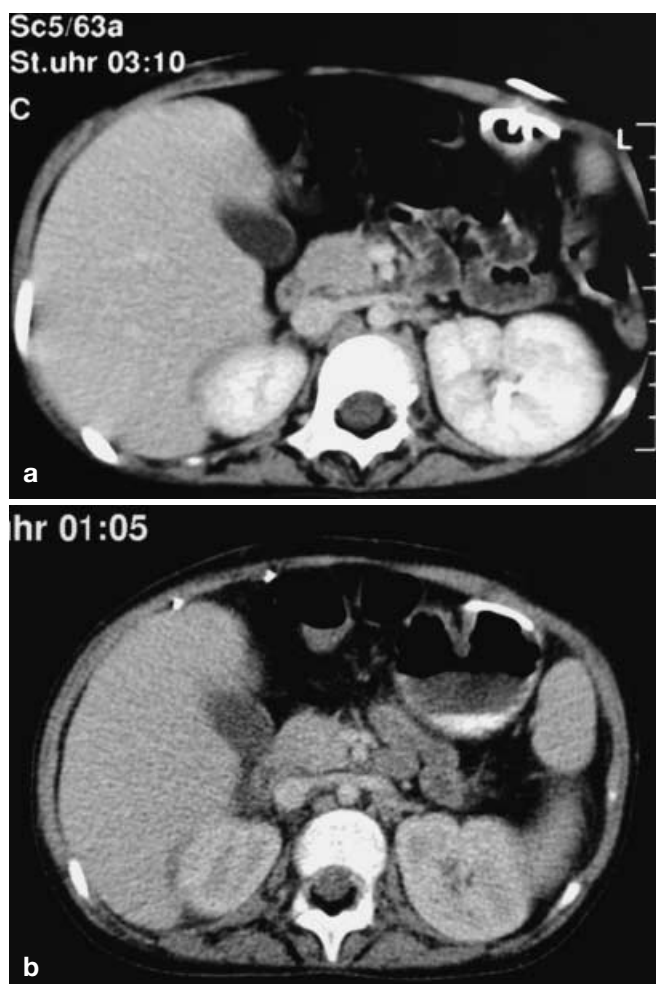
Two contrast-enhanced computed tomography (CT) scans of the same 6-year-old boy done 7 weeks apart (obtained because of fever of unknown origin): (a) obtained with 100 kVp, 175 mAs, pitch 1, rated 1.40 ± 0.55 for image impression and 1.46 ± 0.26 for detail visibility; (b) obtained with a low-dose protocol (100 kVp, 50 mAs, pitch 1) with 29% of radiation exposure compared to (a), which was rated 2.40 ± 0.55 for image impression and 2.16 ± 0.38 for detail visibility. Both scans provide sufficient diagnostic information
